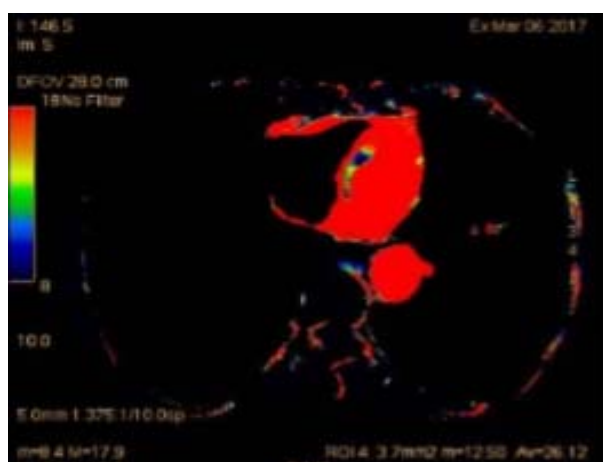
Axial CT of thorax with perfusion map placed over mass in left upper lobe showing BV= 26ml/100ml
